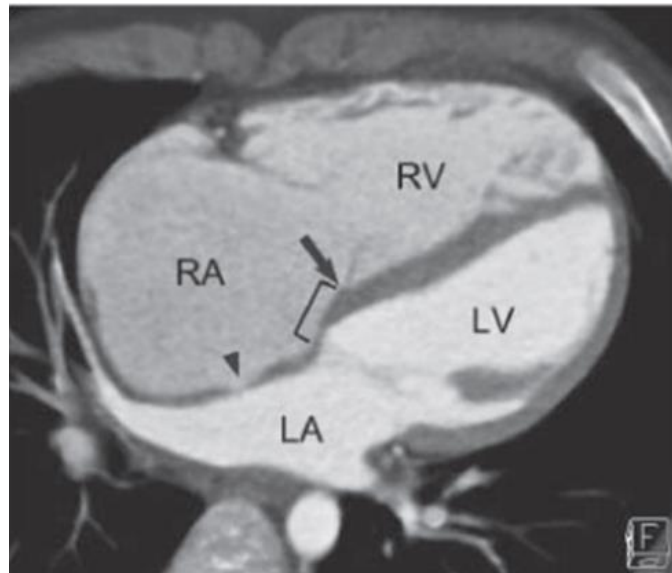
4-chamber cardiac CT view shows the four chambers and their relationships. The tricuspid valve (arrow) is slightly apical than mitral valve. The fossa ovalis is seen (arrowhead) (*Quoted from Goo, 2011*).
